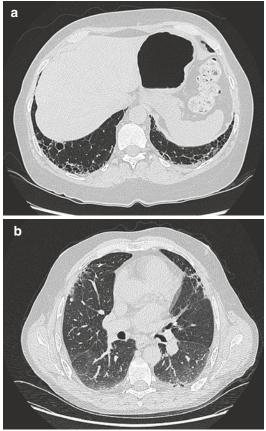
CT chest showing (a) basal pulmonary fibrosis with honeycombing and (b) ground glass opacification on the dorsal side
